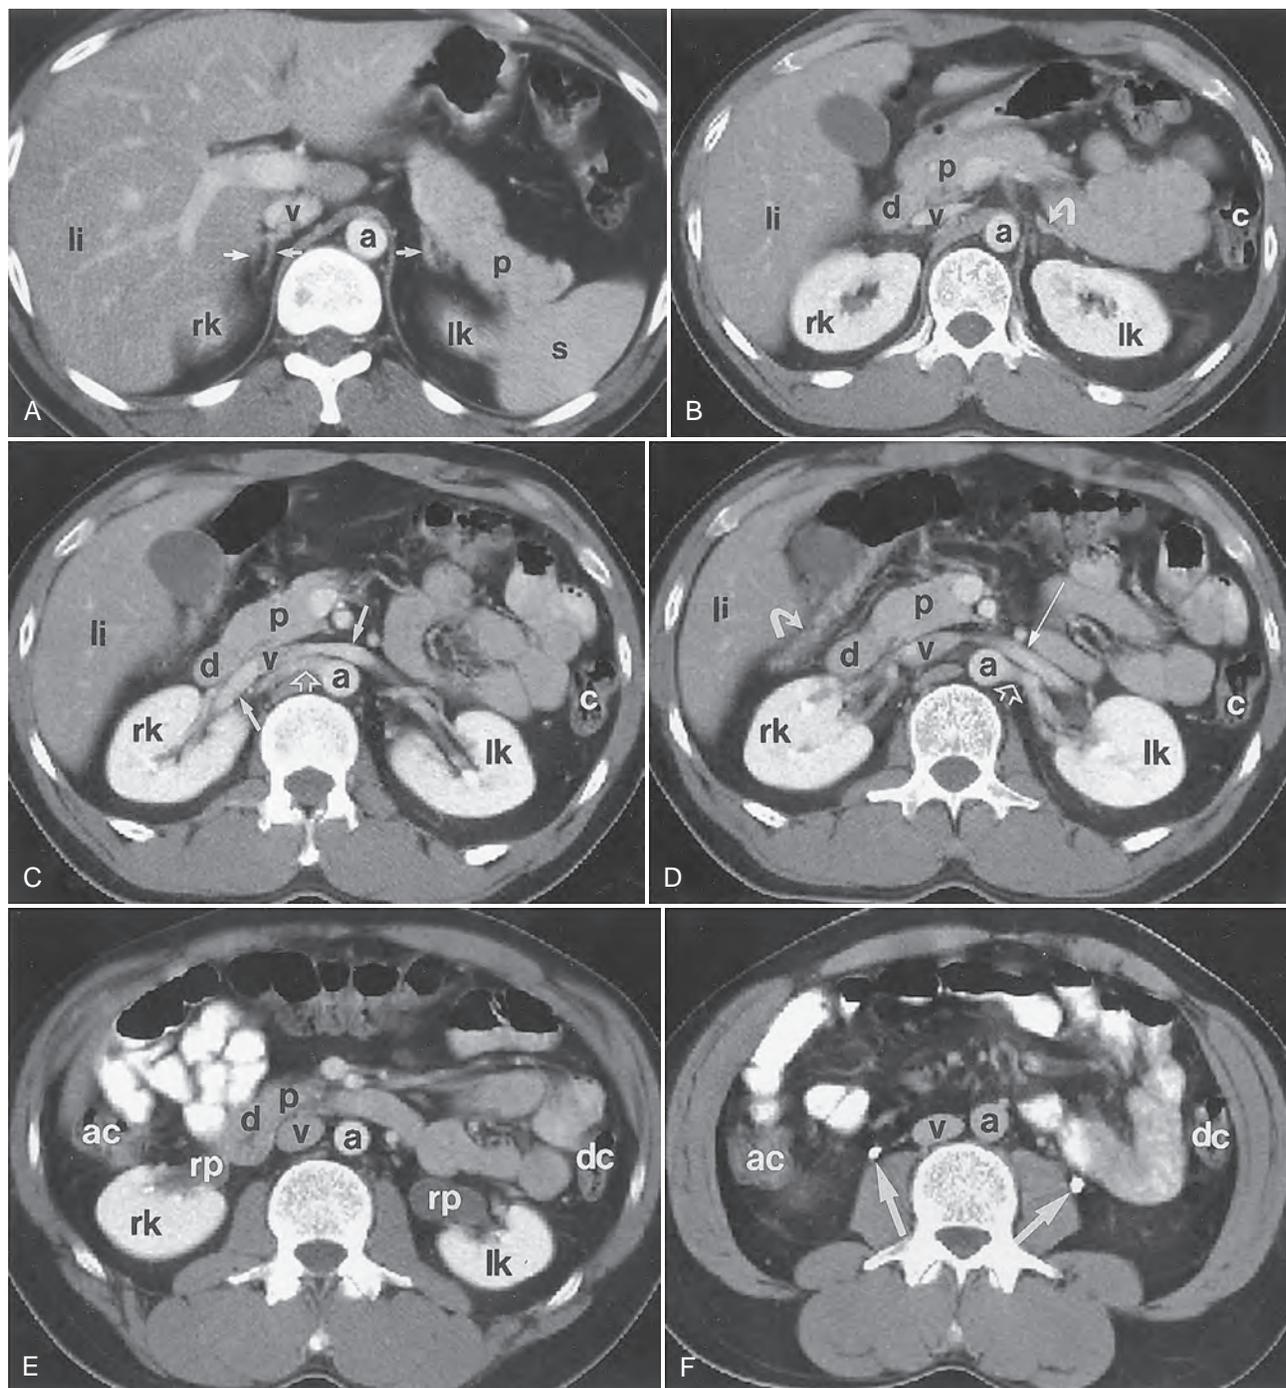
CT of the abdomen and pelvis demonstrating normal genitourinary anatomy. (A) The adrenal glands are indicated with *arrows*. The upper pole of the right and left kidneys is indicated with *rk* and *lk*, respectively. *a*, aorta; *li*, liver; *p*, pancreas; *s*, spleen; *v*, inferior vena cava. (B) Scan through the upper pole of the kidneys. The left adrenal gland is indicated with an *arrow*. *a*, aorta; *c*, colon; *d*, duodenum; *li*, liver; *lk*, left kidney; *p*, pancreas; *rk*, right kidney; *v*, inferior vena cava. (C) Scan through the hilum of the kidneys. The main renal veins are indicated with *solid arrows*, and the right main renal artery is indicated with an *open arrow*. *a*, aorta; *c*, colon; *d*, duodenum; *li*, liver; *lk*, left kidney; *p*, pancreas; *rk*, right kidney; *v*, inferior vena cava. (D) Scan through the hilum of the kidneys slightly caudal to C. The left main renal vein is indicated with a *solid straight arrow*, and the left main renal artery is indicated with an *open arrow*. The hepatic flexure of the colon is indicated with a *curved arrow*. *a*, Aorta; *c*, colon; *d*, duodenum; *li*, liver; *lk*, left kidney; *p*, pancreas; *rk*, right kidney; *v*, inferior vena cava. (E) Scan through the mid to lower polar region of the kidneys. *a*, Aorta; *ac*, ascending colon; *d*, duodenum; *dc*, descending colon; *lk*, left kidney; *p*, pancreas; *rk*, right kidney; *rp*, renal pelvis; *v*, inferior vena cava. (F) CT scan obtained below the kidneys reveals filling of the upper ureters (*arrows*). The wall of the normal ureter is usually paper thin or not visible on CT. *a*, aorta; *ac*, ascending colon; *dc*, descending colon; *v*, inferior vena cava.
